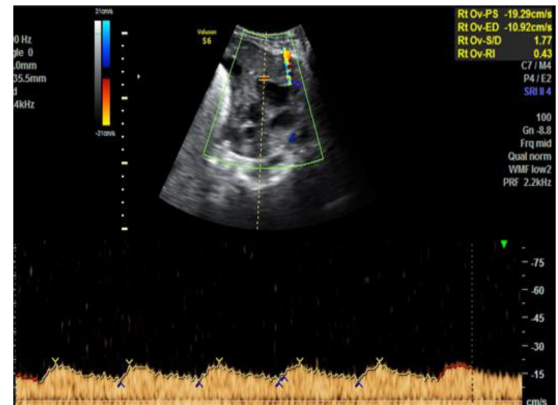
On Doppler examination, lesion showed internal vascularity, with low resistance blood flow, Resistance Index : 0.43 --Malignant ovarian mass
